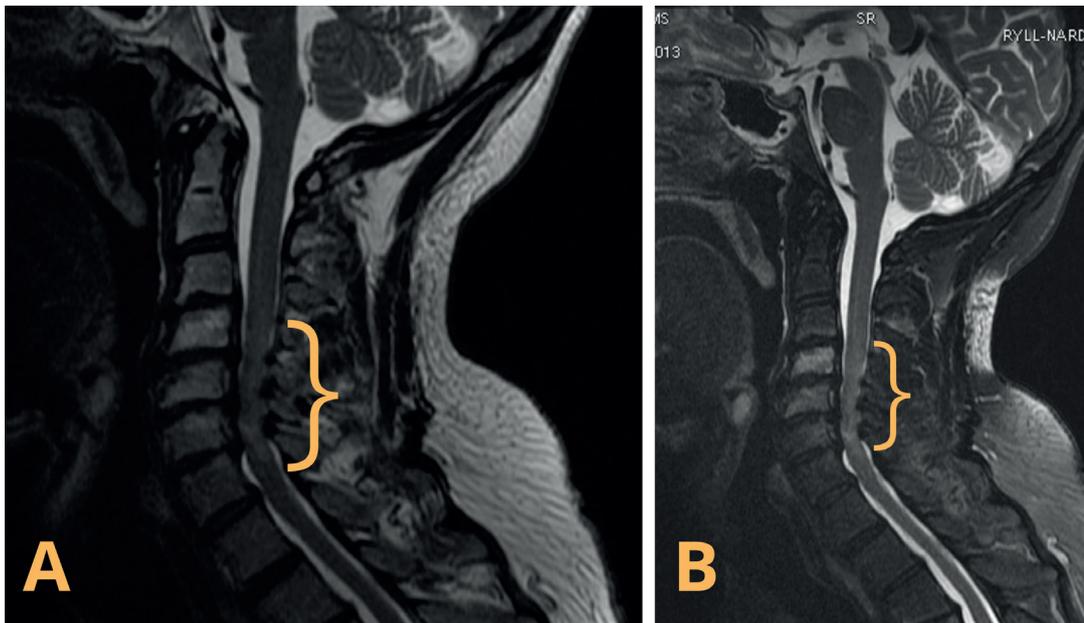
Sagittal T2-weighted (A) and T2-weighted fat-suppressed (B) magnetic resonance (MR) images of the cervical spine in a patient with myelopathy show marked spinal canal stenosis involving the C4–C7 segment of the spine (brackets) with secondary hyperintense changes in the spinal cord
